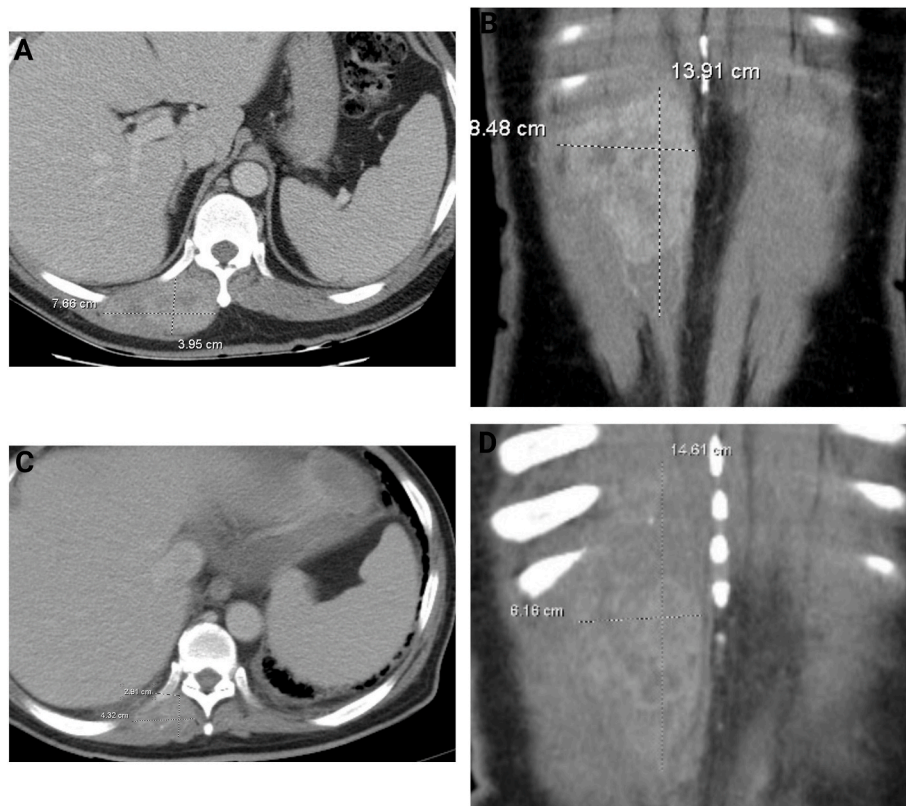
Computed tomography with contrast of the paraspinal muscle mass. Axial view (A) and coronal view (B), original scan from outside study performed on 5/12/2022. Axial view (C) and coronal view (D), follow up scan on 8/15/2022.
